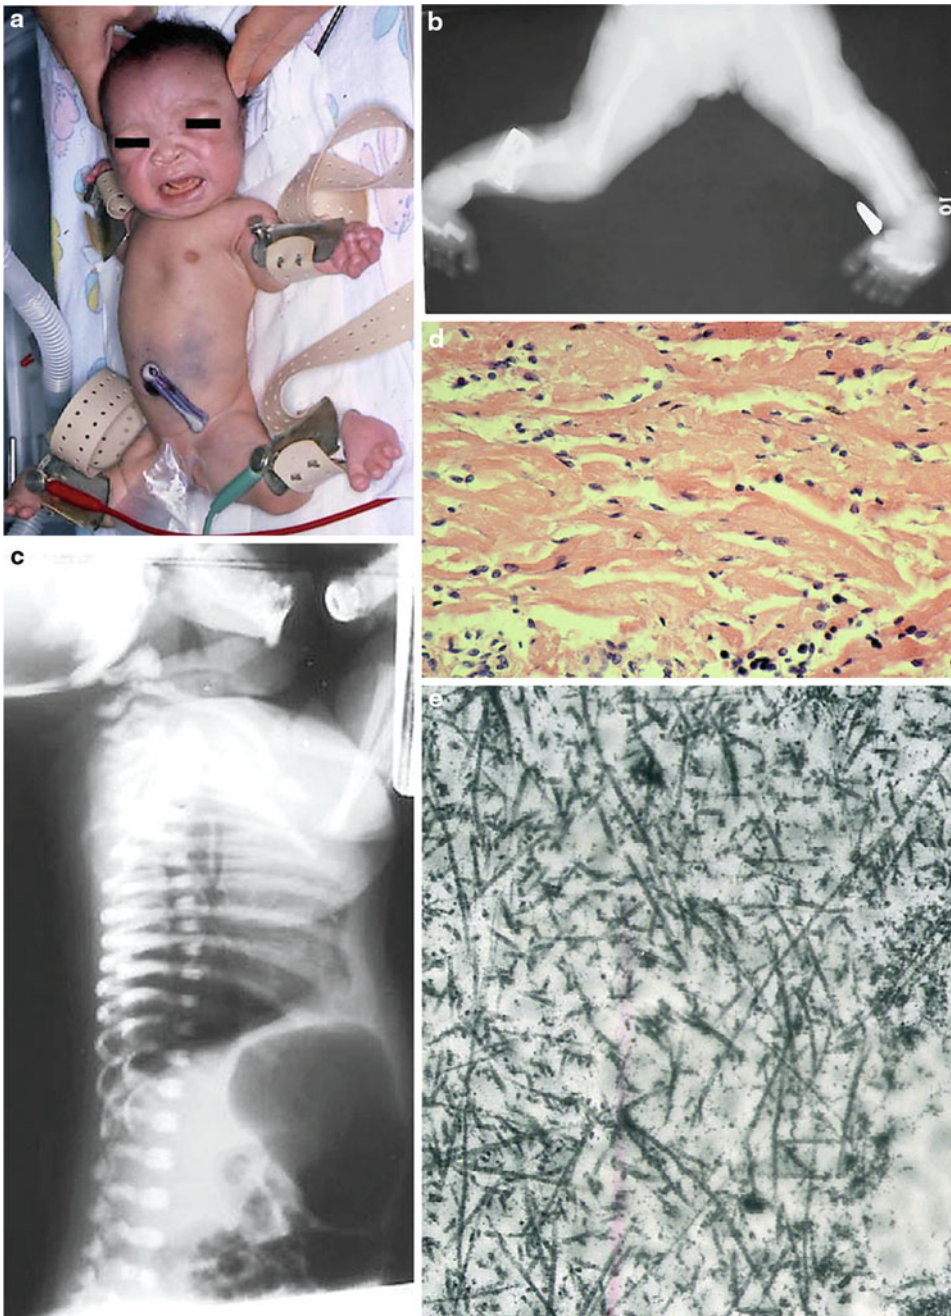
(a–e) An infant with lethal, Larsen-like syndrome (a) showing characteristic flat facies (prominent forehead, hypertelorism, depressed nasal bridge, micrognathia, and cleft palate); multiple dislocations involving shoulders, elbows, wrists, knees, ankles, and hips; and talipes equinovarus. The radiographs showed anterior dislocation of the tibia, lateral dislocation of the hips, hypoplasia of fibulae and of distal ends of the fibulae (b), cervical
